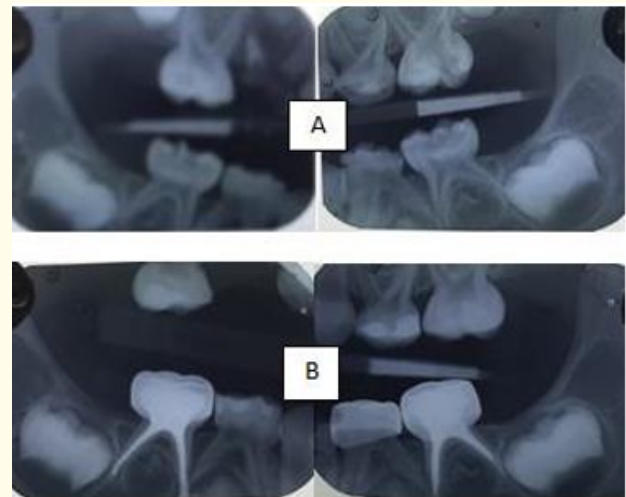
In vivo* case. A. Bite wings of the teeth before treatment. B. Post-operative X-rays of the second deciduous molars treated with SAF system (left) and K-files (right).
